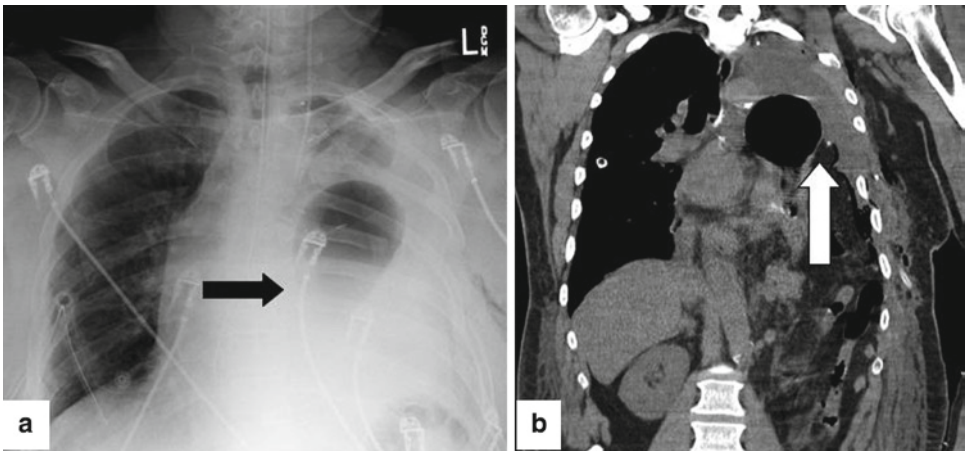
(a) Radiograph showing herniation of stomach above the diaphragmatic reconstruction. (b) Coronal reformat showing the stomach above the gore-tex reconstruction (*white arrow*)
